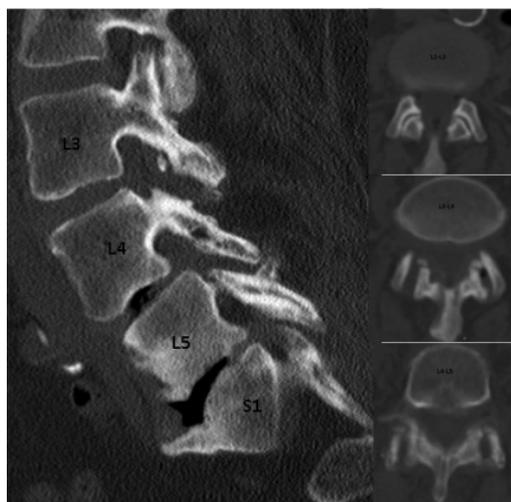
CT scan of her lumbar spine demonstrates intact C2-3 facets, however, there was severe widening of bilateral facet at L3-L4 and L4-L5.
